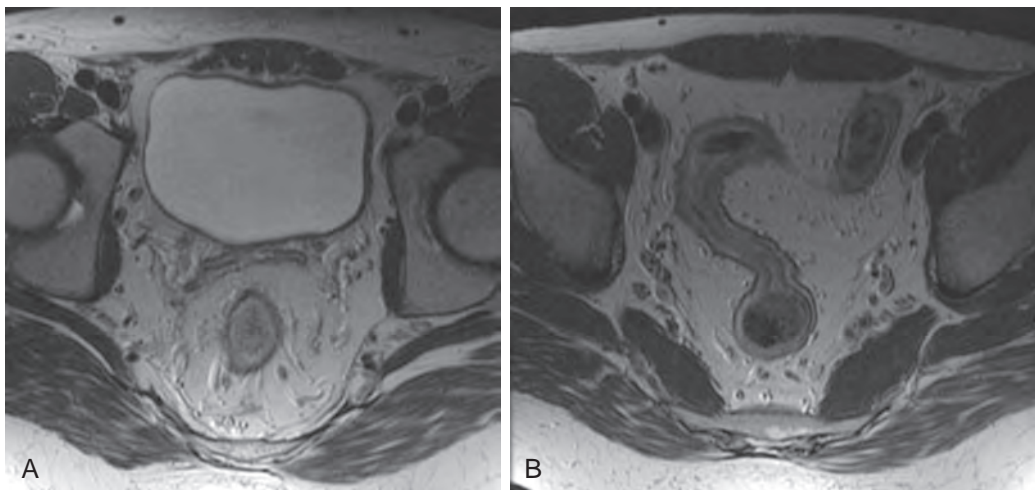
Ulcerative colitis: MR findings. T1-weighted axial MR images of the rectum (A) and rectosigmoid junction (B) show mural thickening of the colon, submucosal fat deposition, increased presacral fat, and prominent vessels in the mesorectal fat.
